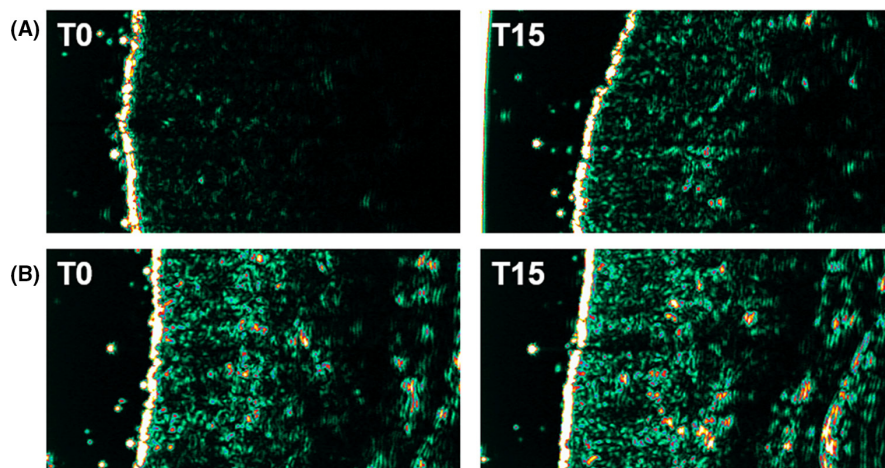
Dermis echogenicity accessed with high-frequency ultrasound. The brighter the pixels, the most echogenic is the dermis. The participants with erythema (A) presented a low density of bright pixels in the initial time and after 15 days the images improved. For the participants with photoprotection habits (B), a high echogenicity dermis was always observed.
